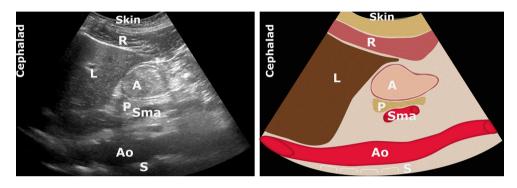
Sonographic image of the stomach showing "late stage" solid gastric contents. A = antrum; Ao = aorta; L = liver; P = pancreas; R = rectus abdominis muscle; S = spine; Sma = superior mesenteric artery. Used with permission from gastricultrasound.org
